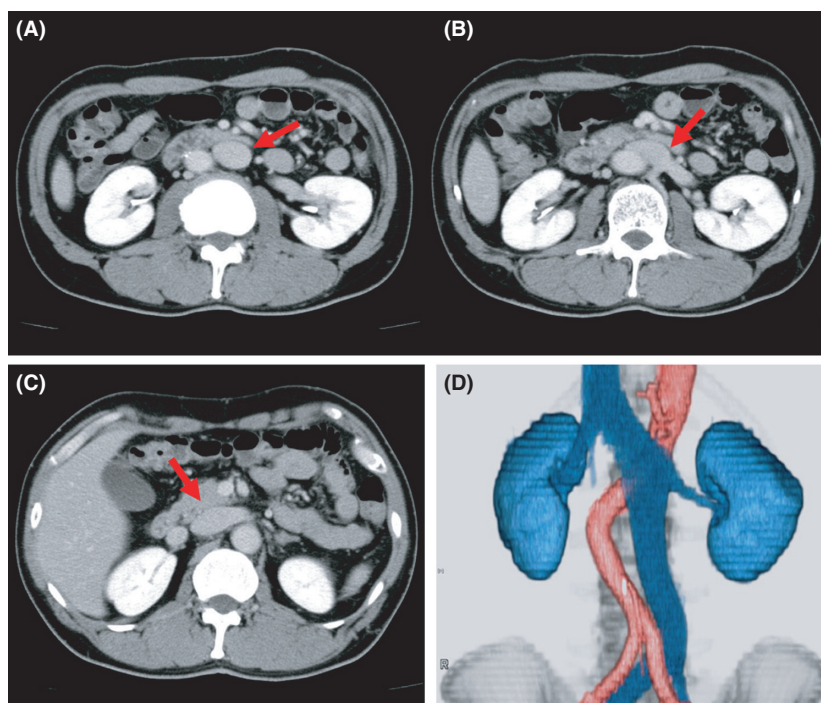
Abdominal CT scan showing the left IVC (arrow) inferior to the renal vein (A). The left IVC joins the left renal vein (B). Then, the IVC crosses anterior to the aorta in the normal side (C). Panel D showing 3D image.
